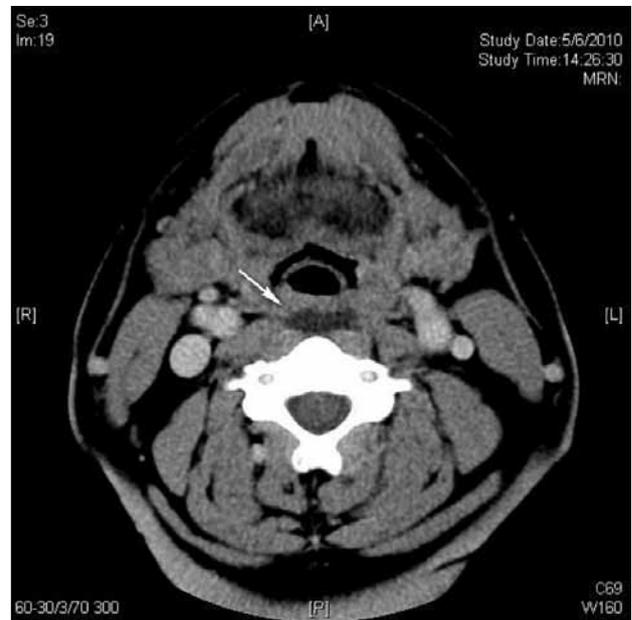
An axial contrast computed tomographic image shows a fluid collection (arrow) without an enhancing rim smoothly expanding the retropharyngeal space. Peripheral fat planes were preserved. No enlarged cervical lymph node was detected (not shown).
